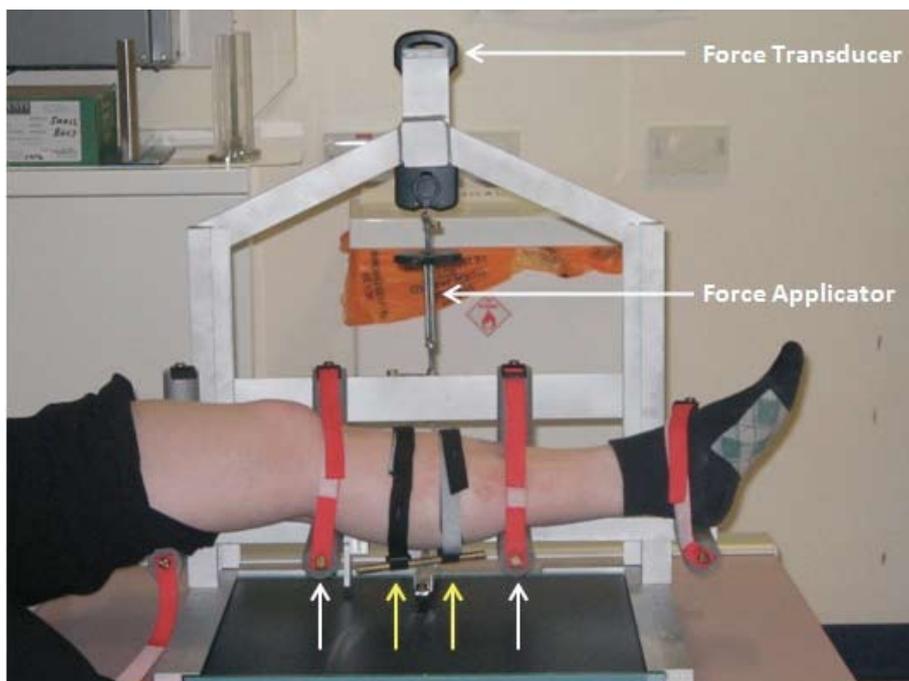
The four-point bending frame during an AP X-ray of a patient, showing the inner (yellow) and outer (white) fulcra, the force applicator and the force transducer.
